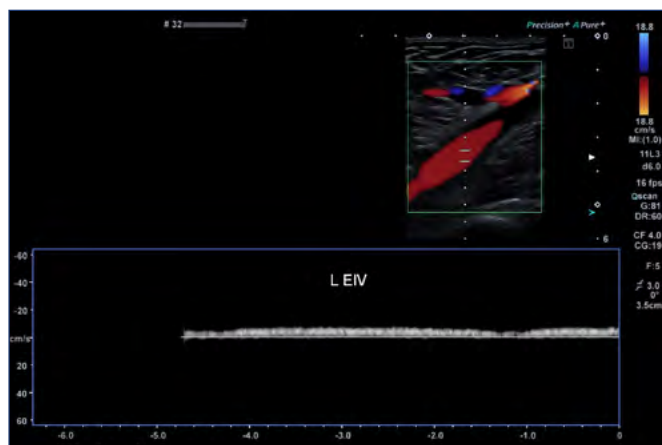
Although there is normal color flow in the left external iliac vein (L EIV), the Doppler signal suggests otherwise—note the flat tracing with minimal to no respiratory variability. There is a more central inferior vena cava (IVC) and iliac venous obstruction. Ultrasound demonstrates physiological changes as well as simple anatomical abnormalities.
